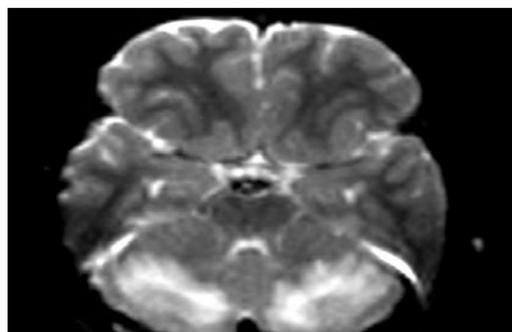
DWI image Patch deeply seated parenchymal areas of diffusion restriction as well as micro-hemorrhages.
